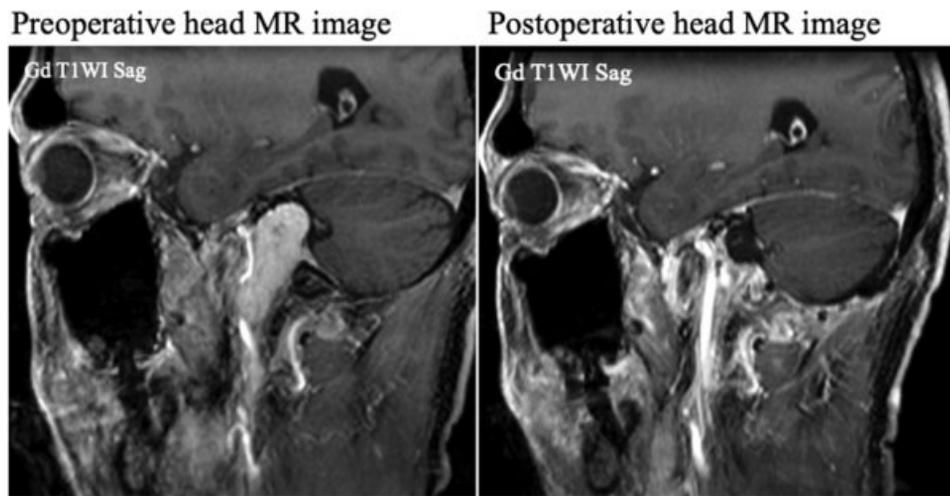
Pre- and postoperative MR images. MR, magnetic resonance.
